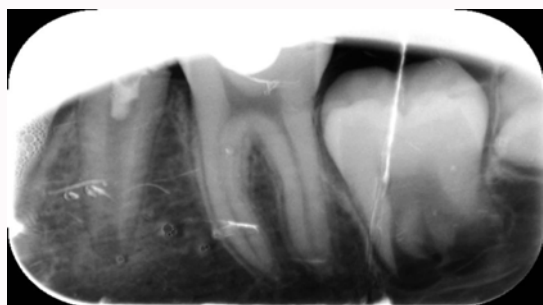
A periapical radiograph at the start of the treatment.
